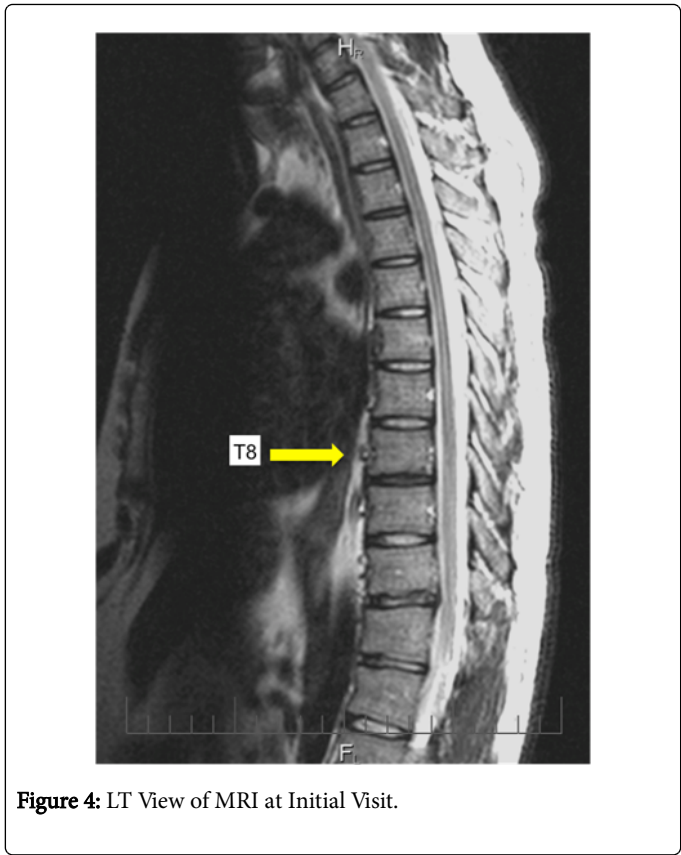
LT View of MRI at Initial Visit.
